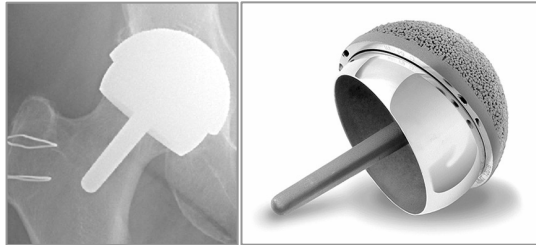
Radiograph of HRA and the spherical shell and cup of a Birmingham Hip Resurfacing system.
